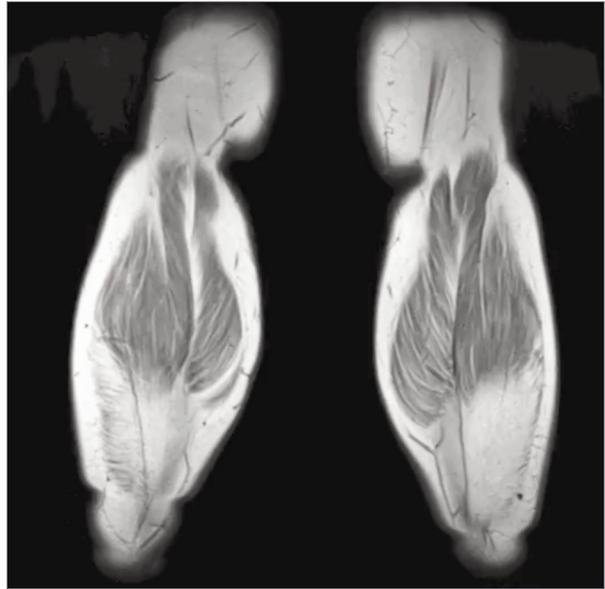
Coronal T1-weighted image of the posterior legs showing diffuse moderate fatty infiltration of both leg muscles.
